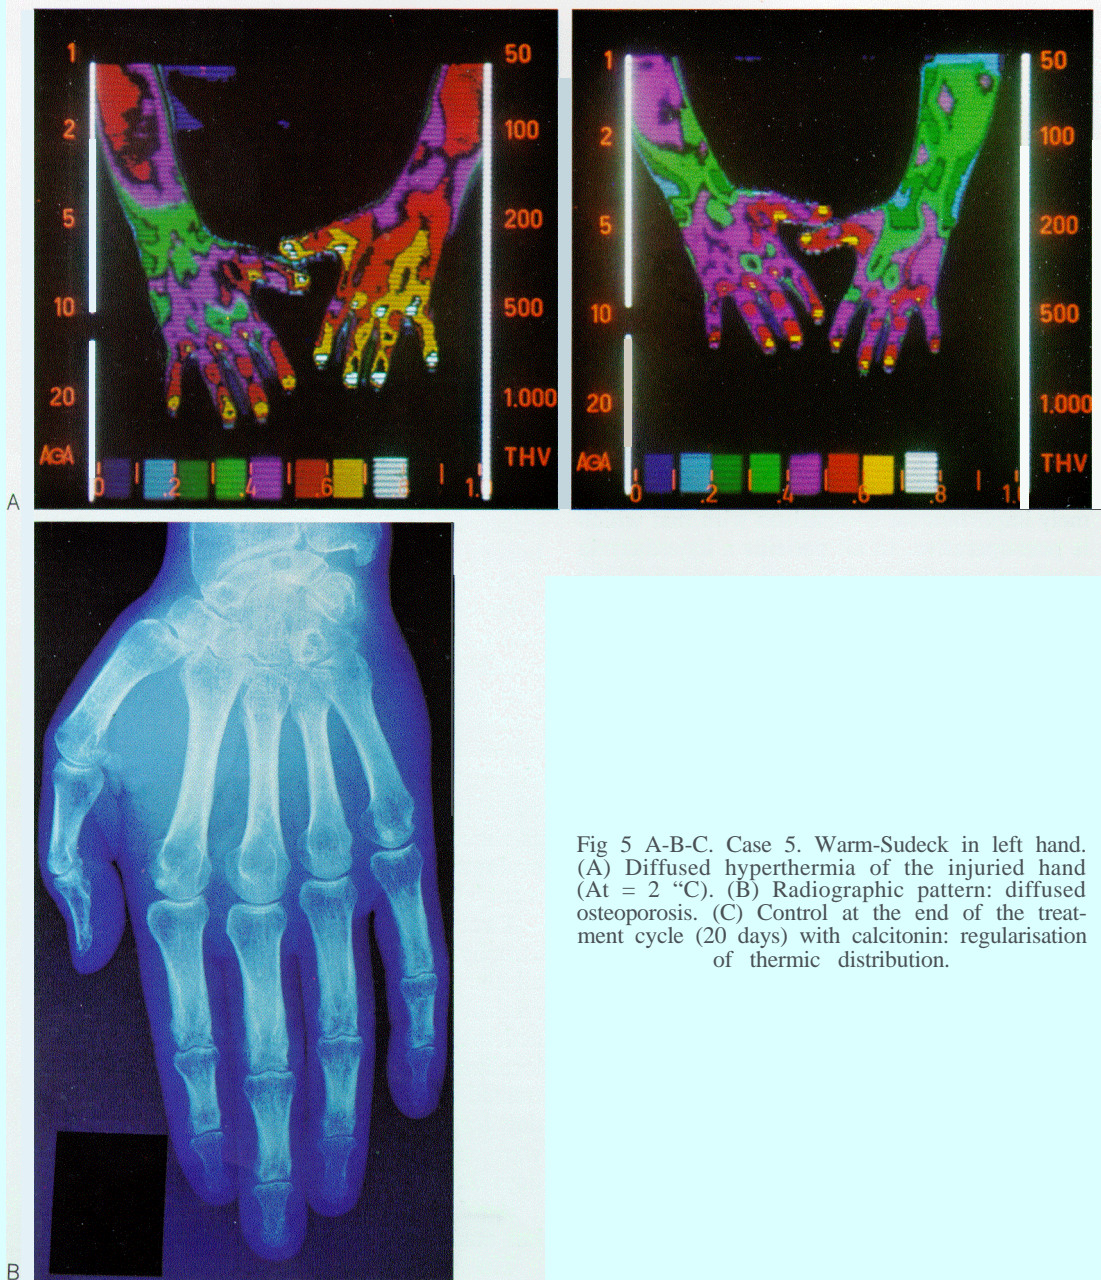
A-B-C. Case 5. Warm-Sudeck in left hand. (A) Diffused hyperthermia of the injured hand ($At = 2^{\circ}C$). (B) Radiographic pattern: diffused osteoporosis. (C) Control at the end of the treatment cycle (20 days) with calcitonin: regularisation of thermic distribution.
